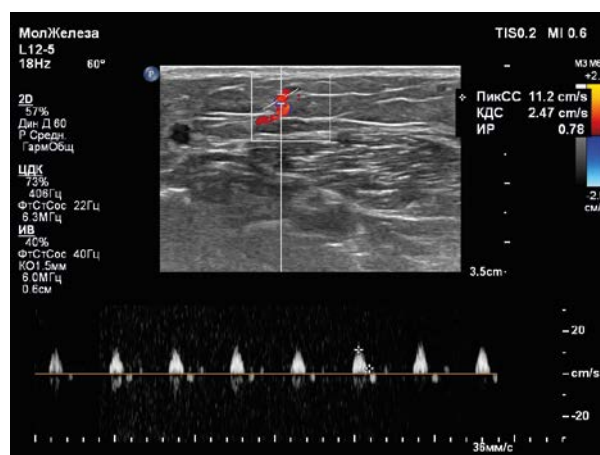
Dopplerometry-determination of maximum velocity parameters in the perforant artery (MAS-11.2 cm / s).
